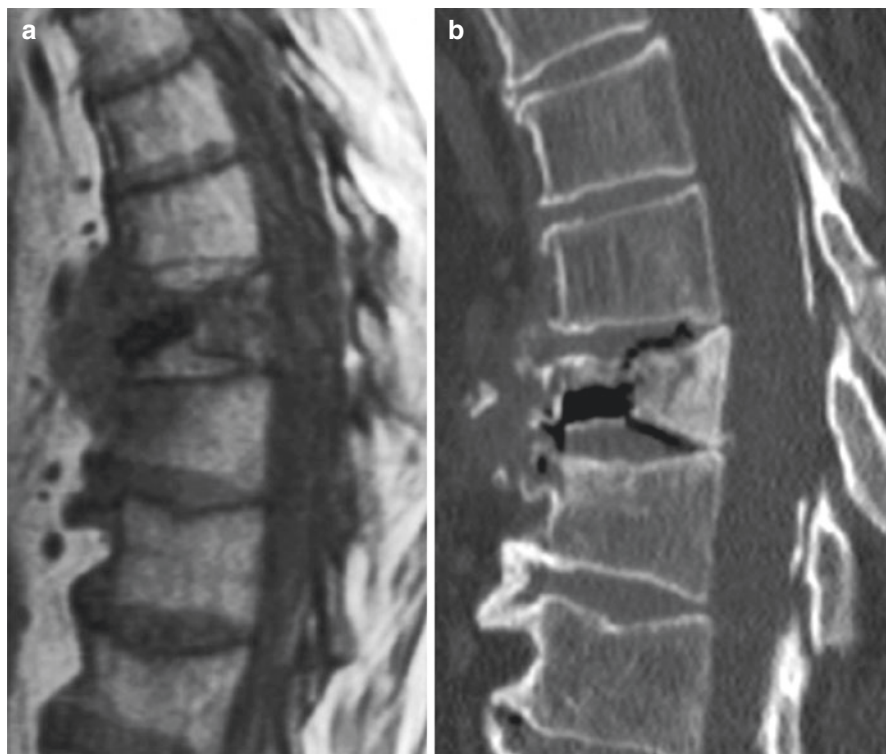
(a, b) Sagittal T1-WI in a patient with an acute compression fracture (a). The presence of an intervertebral vacuum cleft sign on CT (b) confirmed the diagnosis of an osteoporotic fracture
